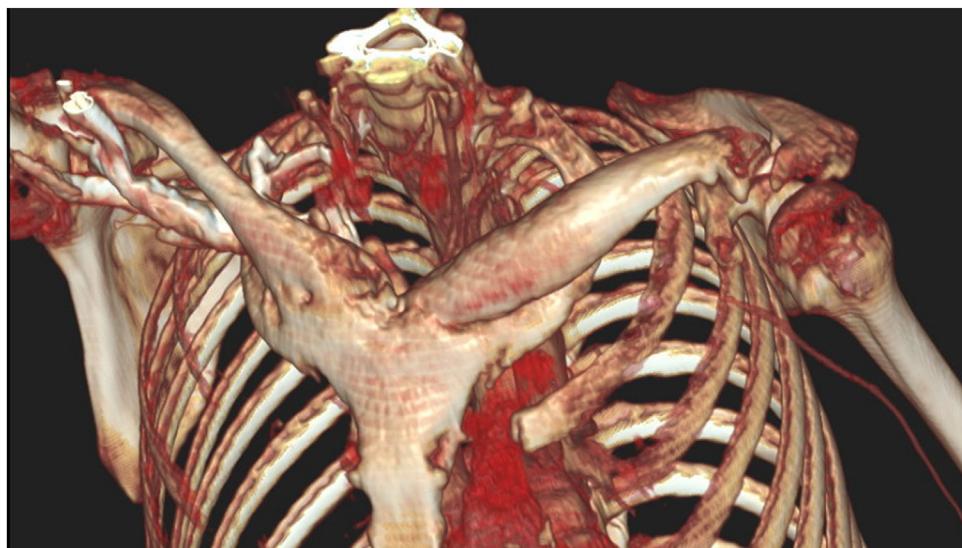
Abbreviations: SAPHO, synovitis–acne–pustulosis–hyperostosis–osteitis; TOS, thoracic outlet syndrome; nTOS, neurogenic thoracic outlet syndrome; aTOS, arterial thoracic outlet syndrome; vTOS, venous thoracic outlet syndrome; CT, Computed tomography.
